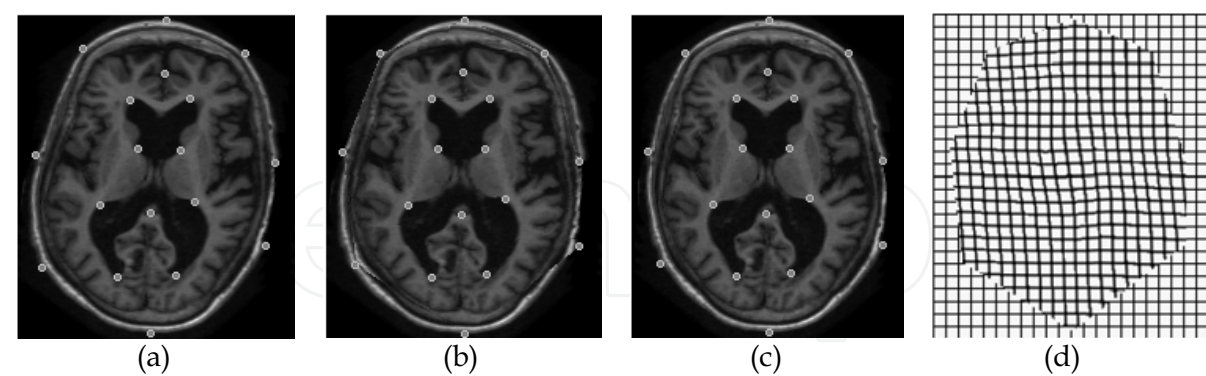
Example of MRI image registration with direct composition of affine transformations. Input image (a), registered image (b) and target image (c). Deformed grid in (d). In this example 18 landmark points were used.
